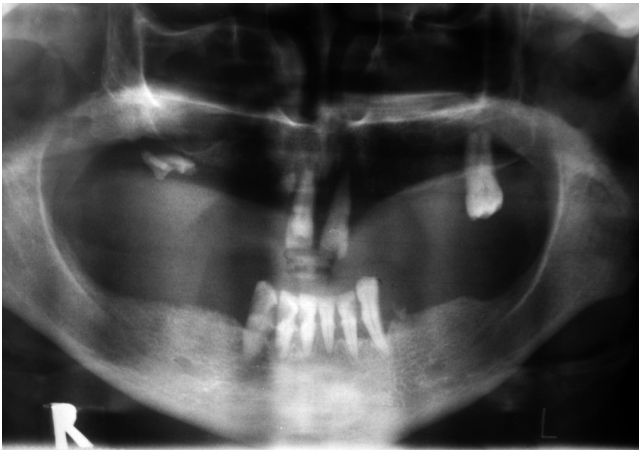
Panoramic radiograph did not show any pathological features in the jaw.
